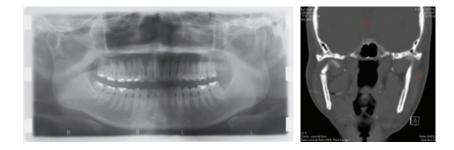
Preoperative panoramic film showed the right condyle, left parasymphyseal and body fractures (left). Computerized tomograghy (CT) showed marked displacement of the condyle (Right).
